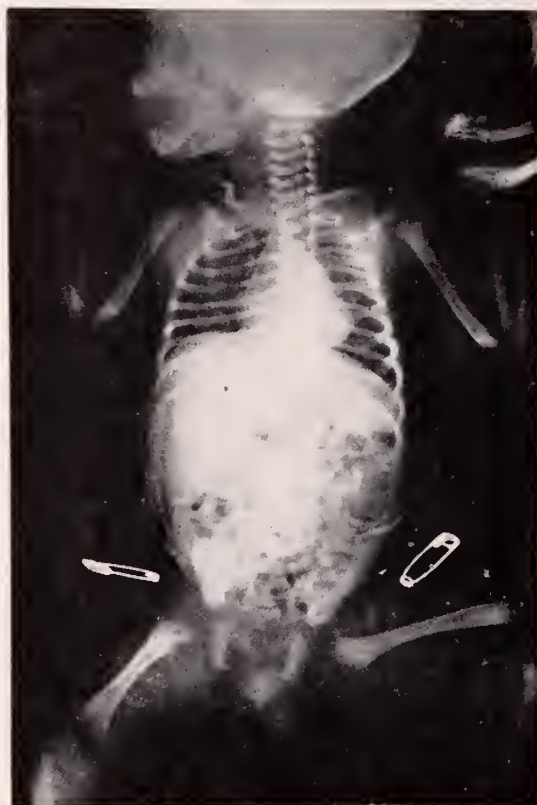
Roentgenogram of Case No. 2 at two months of age.
